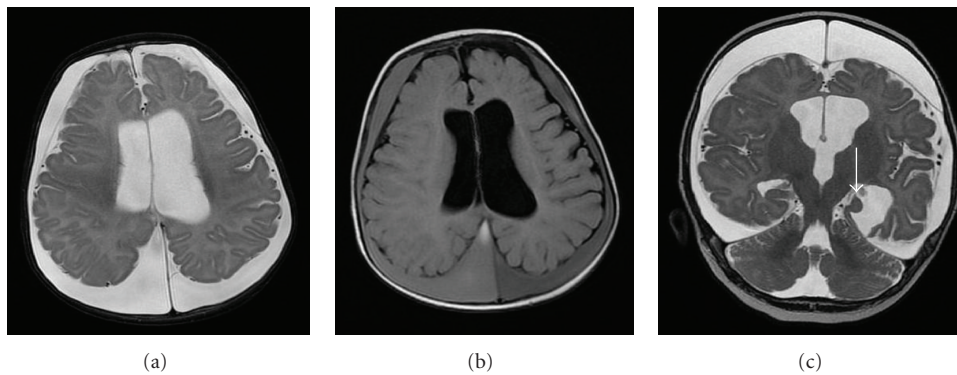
A 4-month-old infant was presented with a large head circumference followed by seizure-like episodes. Axial T2-weighted image (a) showed hydrocephalus and prominent CSF space along bilateral cerebral convexities. The fluid was subdural hematomas because the signal intensity of the fluid is different from that of CSF on FLAIR T2-weighted image (b). Coronal T2-weighted image showed hypoplasia of the left hippocampus.
